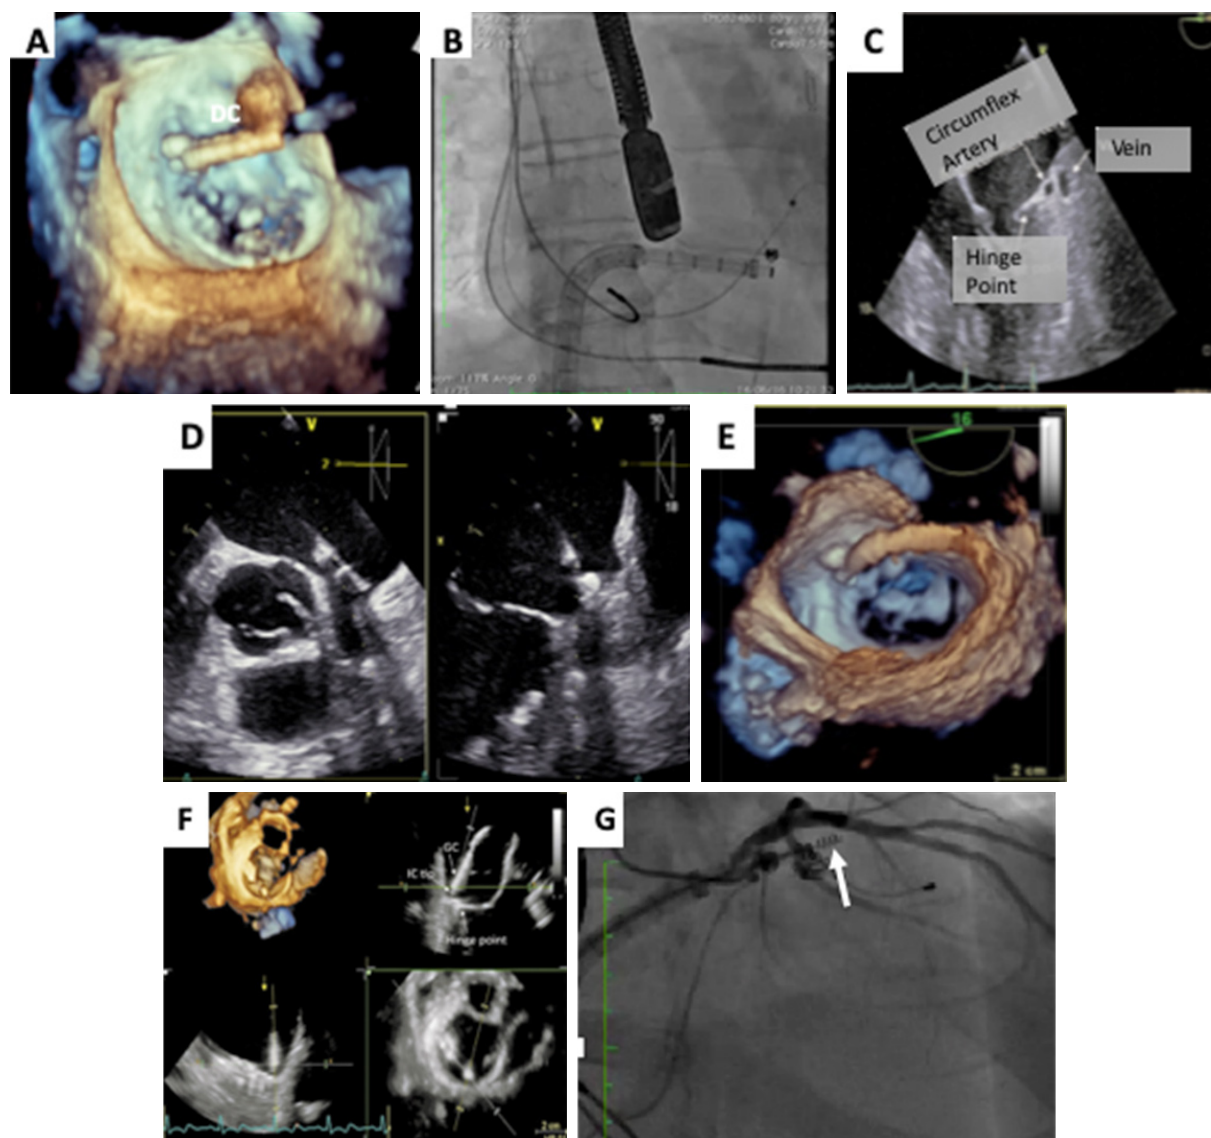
Navigation inside left atrium and Implant deployment. DC positioned at level of anterior commissure: A: 3D overhead perspective; B: AP fluoroscopic projection; C: echocardiographic localization of circumflex artery; D: biplane imaging for fine tip positioning on the annulus and assessing the local angle of approach to the annulus; E: 3D MV en face view showing spatial relationships during deployment of first anchors in antero-lateral commissural area; F: multiplanar reconstruction showing anchor delivering; G: coronary angiography: spatial relationship between anchor (white arrow) and circumflex artery. DC: delivery catheter; AP: antero-posterior; MV: mitral valve
